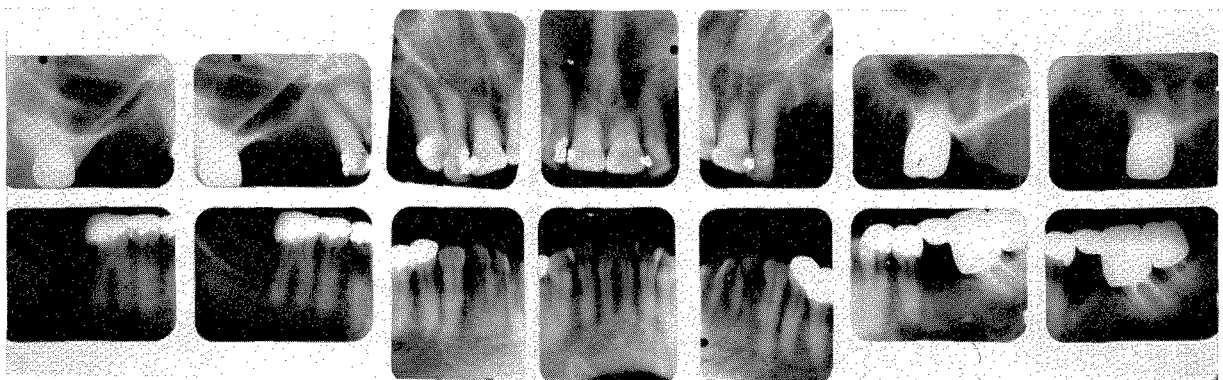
Roentgenograms taken in 1934. The work was completed.
